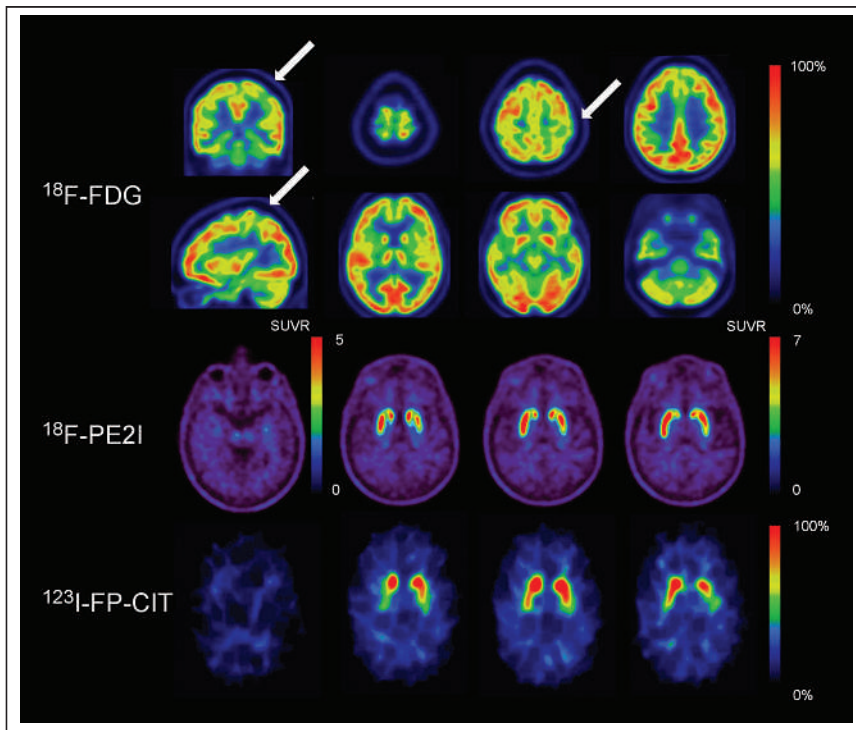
(Top) Orthogonal ^{18}F -FDG PET slices showing mild hypometabolism (arrows) in left sensorimotor cortex corresponding to right arm location of cortical homunculus. (Middle and bottom) Transverse slices of dopamine transporter imaging. Both classic ^{123}I -FP-CIT SPECT and high-resolution, selective ^{18}F -PE2I PET showed normal presynaptic dopaminergic uptake. Images are in radiologic orientation. SUVR = SUV ratio.
